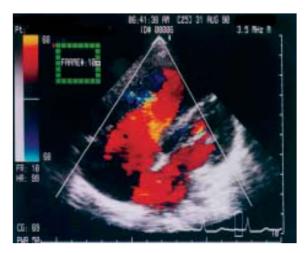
Four-chamber view is showing a large secundum type defect in the atrial septum. Blood flow crossing the ASD is apparent on Doppler echocardiography.
